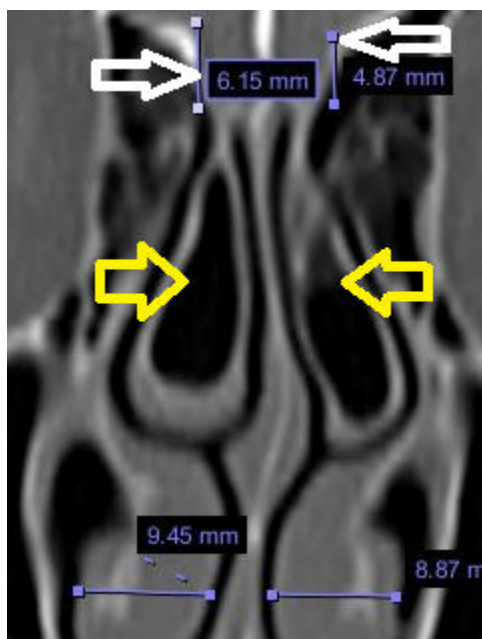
In coronal section of the PSCT, Concha bullosa (yellow arrows) and measurement of cribriform plate lamina lateralis depth (white arrows). PSCT = paranasal sinus computed tomography
